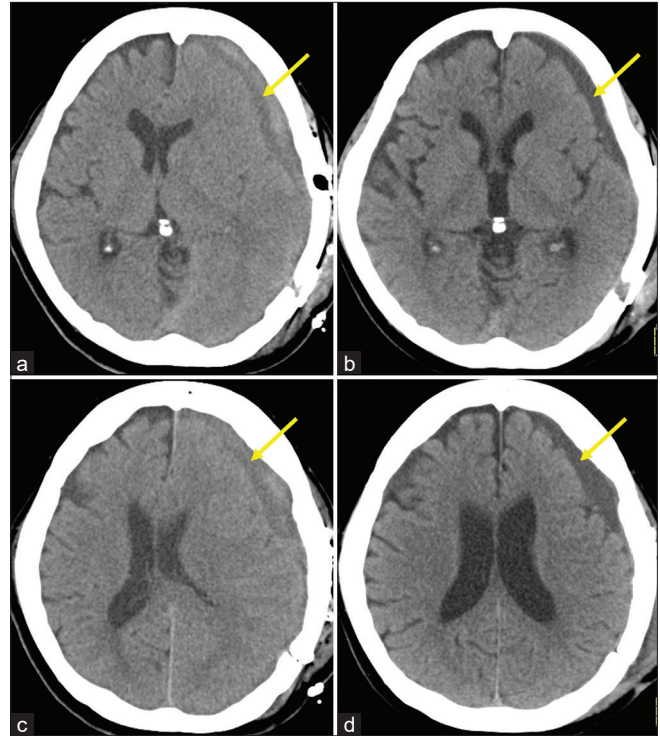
Axial computed tomography scans performed on postoperative day 1 (a and b) and day 35 (c and d) showing resolution of the residual subdural hematoma.
